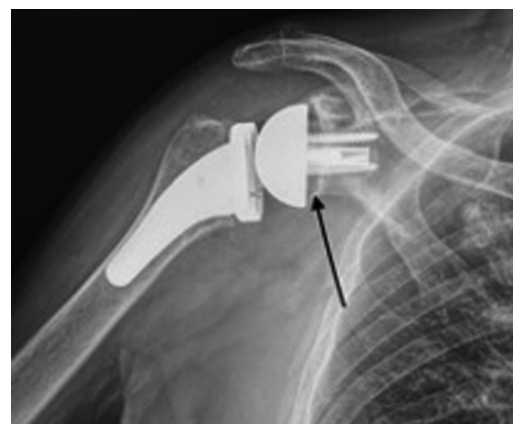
Bony increased offset reverse shoulder arthroplasty (BIO-RSA) follow-up radiograph at 3 months. The black arrow demonstrates the structural bone graft placed behind the glenoid baseplate.
